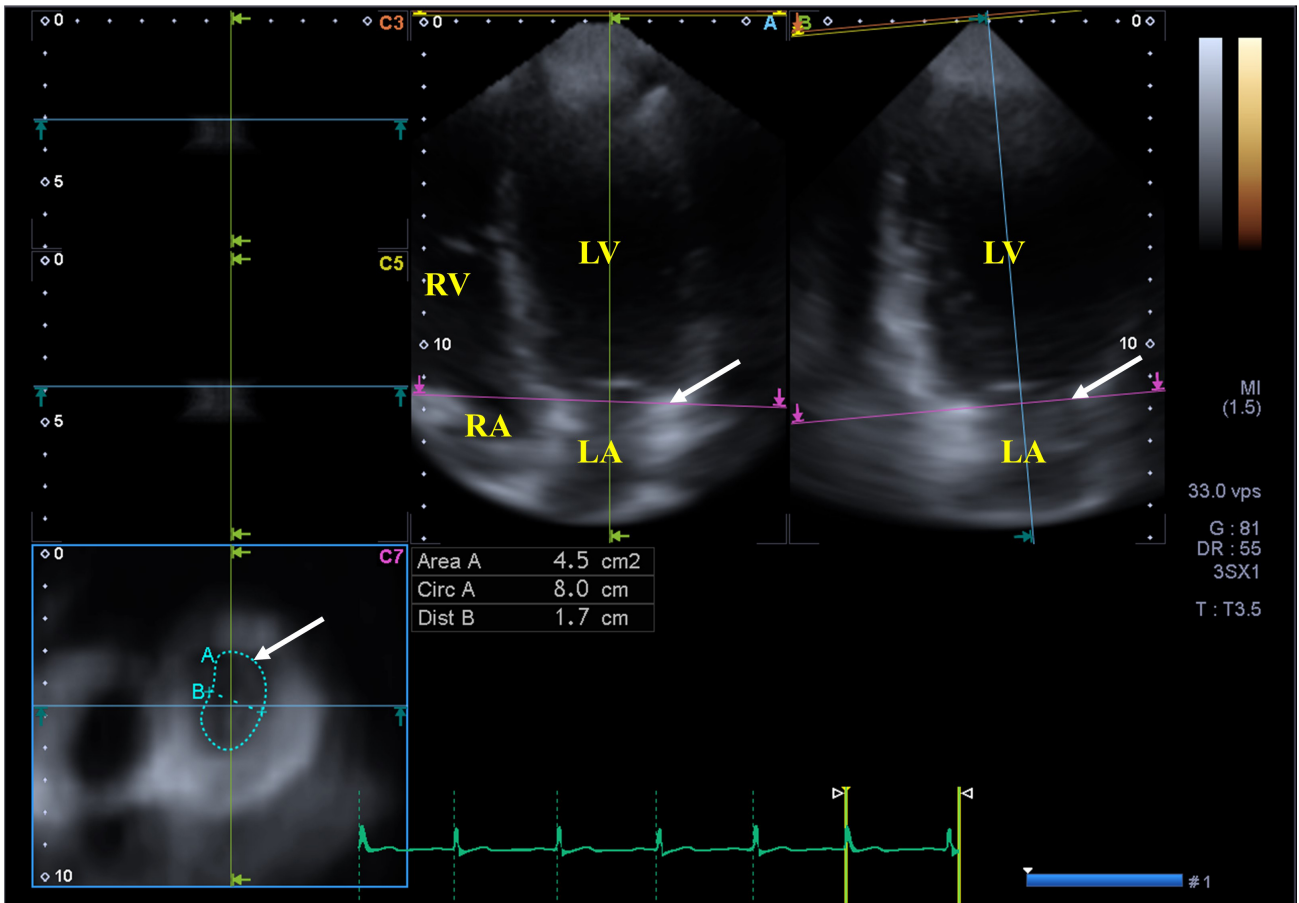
Three-dimensional speckle tracking echocardiography-derived three-dimensional dataset from which the mitral annulus is extracted. (A) Apical four-chamber view, (B) apical two-chamber view and a cross sectional view at the level of the mitral annulus (C7) following optimizations in apical four- and two-chamber views. The mitral annular plane is shown by a white arrow on long- (A, B) and short-axis (C7) images. Abbreviations: LA, left atrium; LV, left ventricle; RA, right atrium; RV, right ventricle; Area, MA area, Circ, MA perimeter, Dist, MA diameter.
